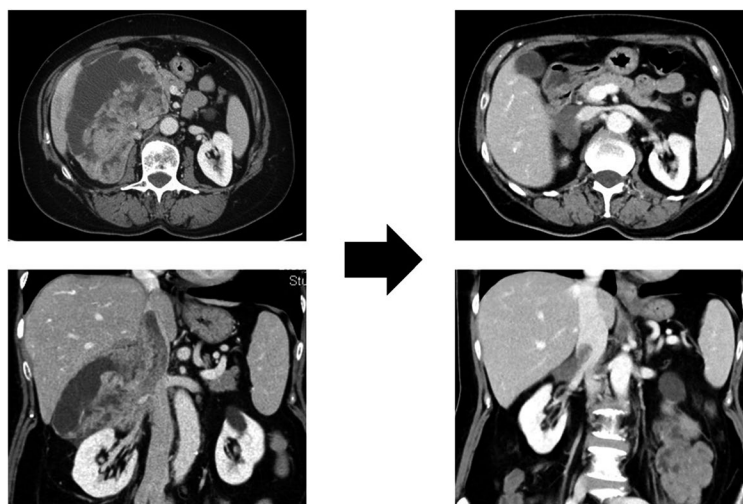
Leiomyosarcoma of the Right Retroperitoneum Originating From the Inferior Vena Cava. Left: (Top) Axial and (Bottom) coronal contrast-enhanced computed tomography images before preoperative chemotherapy are shown. Right: (Top) Axial and (Bottom) coronal contrast-enhanced computed tomography images after 3 cycles of doxorubicin and dacarbazine are shown.
